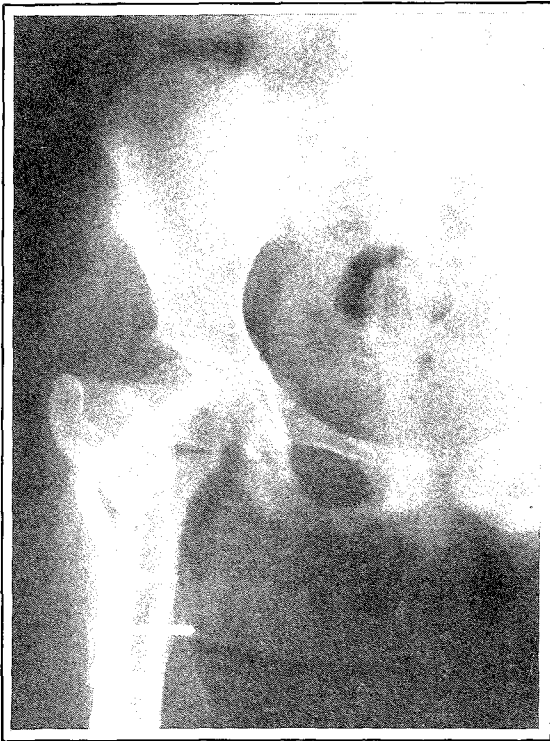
A post-operative radiograph of Case 3, the pseudoarthrosis and osteotomy has united and the neck shaft angle corrected.
